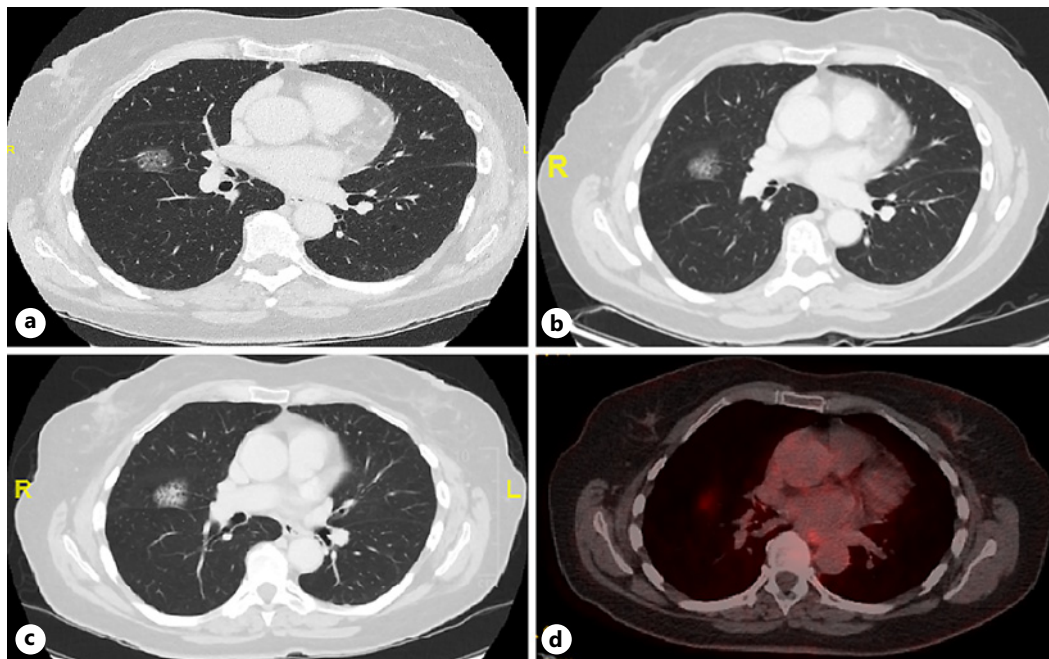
a A CT-TAP taken on December 18, 2018 showing a 2.4 cm rounded ground-glass pulmonary opacity in the middle lobe of the right lung. b A CT thorax taken in July 2019 showing the GGO is stable and measures approximately 2.5 cm. c, d PET-CT whole body taken in September 2019 showing the lesion in the right lung to have increased in size from 16 × 17 × 22 mm to 19 × 28 × 17 mm, displaying low level FDG uptake (maximum SUV 2.6).
